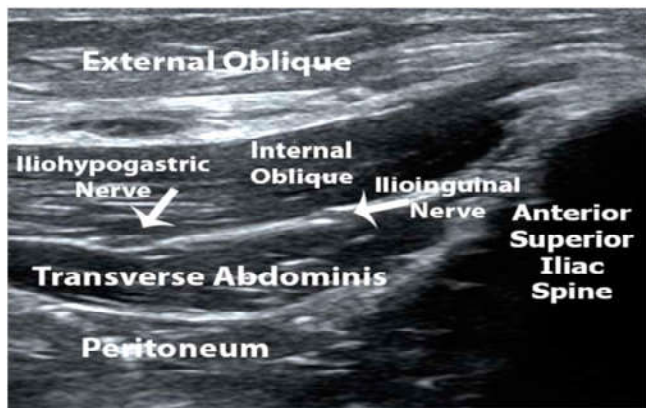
Ultrasound Guided Iliohypogastric Ilioinguinal Nerve Block Image
